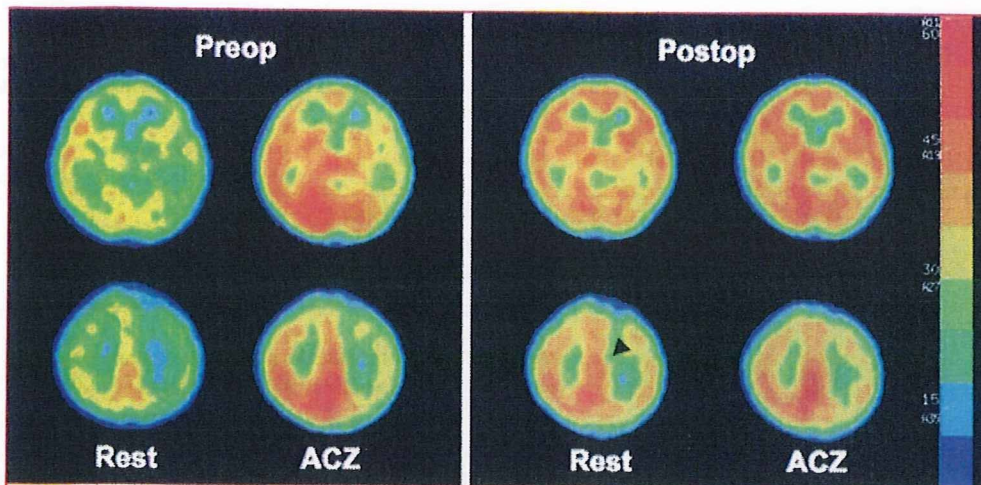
Pre- (left) and postoperative (123I)-IMP single-photon emission computed tomography (right) of an 8-year-old girl who underwent superficial temporal artery to middle cerebral artery anastomosis and encephalo-duro-myo-arterio-pericranial synangiosis on both sides. Before surgery, both cerebral blood flow and its reactivity to acetazolamide (ACZ) were reduced in the right frontal lobe and the entire territory of the left internal carotid artery. These parameters significantly improved or normalized 4 months after surgery, except for a small cortical infarction in the left frontal lobe. Note that both cerebral blood flow and its reactivity to ACZ also improved in the anterior coronary artery territories (arrowhead).
